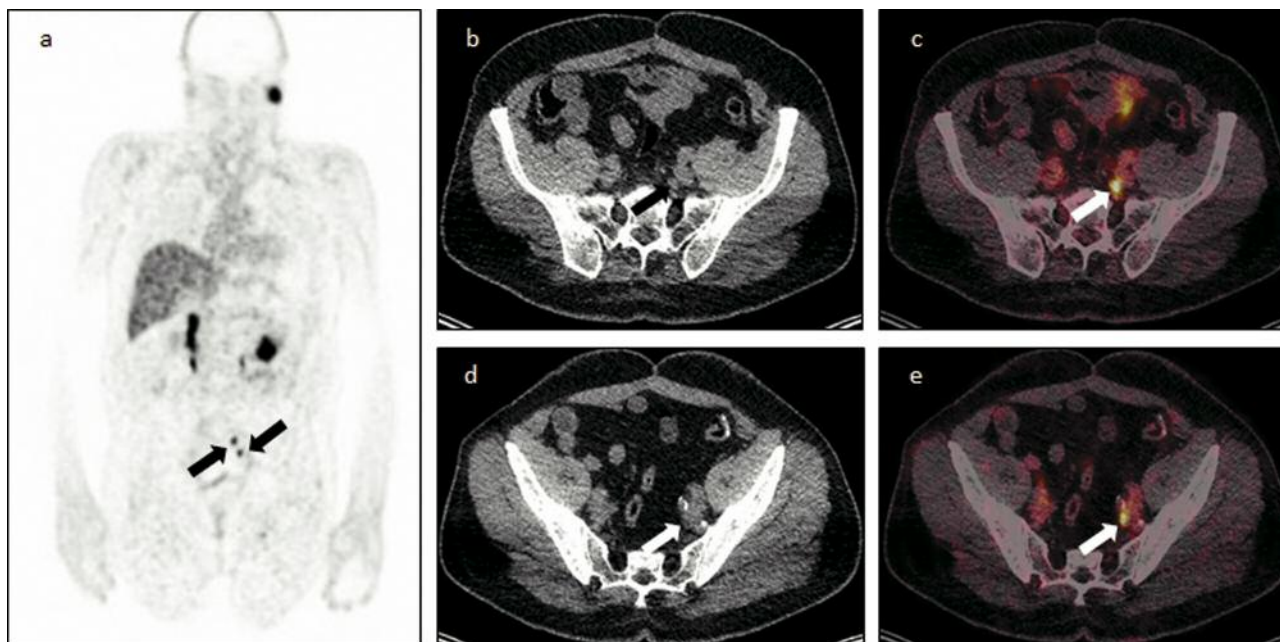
$^{68}\text{Ga}$  prostate-specific membrane antigen ligand positron-emission tomography-computed tomography in a 72-year-old patient. Coronal positron-emission tomography (a), corresponding axial computed tomography (b, d), and fused images (c, e) showing two lymph node metastases (arrows), but no evidence of disease in other localizations.
